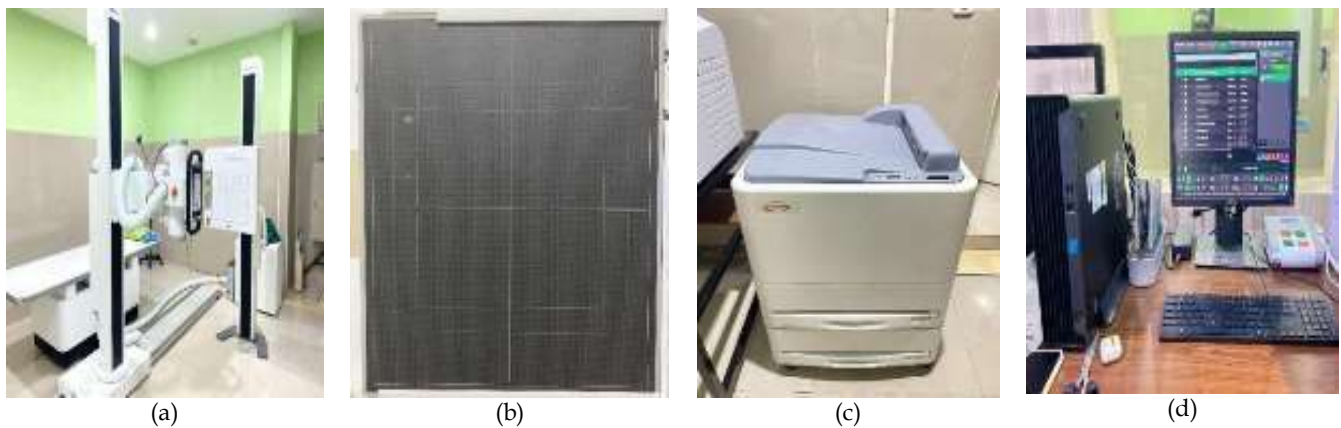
Equipment: (a) X-ray machine, (b) DR detector size 35X43 cm, (c) Image Printers, and (d) Image console
